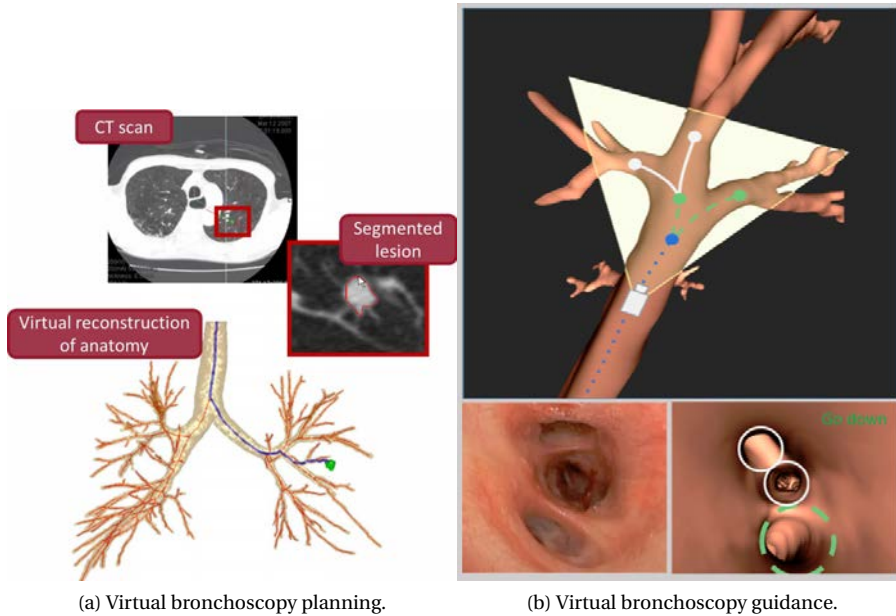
Virtual bronchoscopy system for biopsy intervention guidance. At the planning stage, the volume and the centerline of the airways is extracted from a CT which is used to plan the actual intervention (a). At the intervention stage, the direction to follow at each bifurcation is shown in order to guide the bronchoscopist to reach the target lesion (b).
